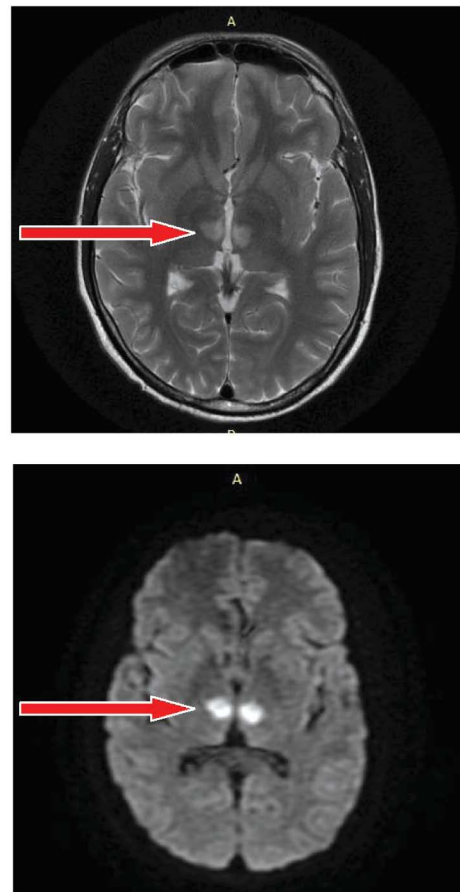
MRI Brain showing infarct in the Artery of Percheron territory
